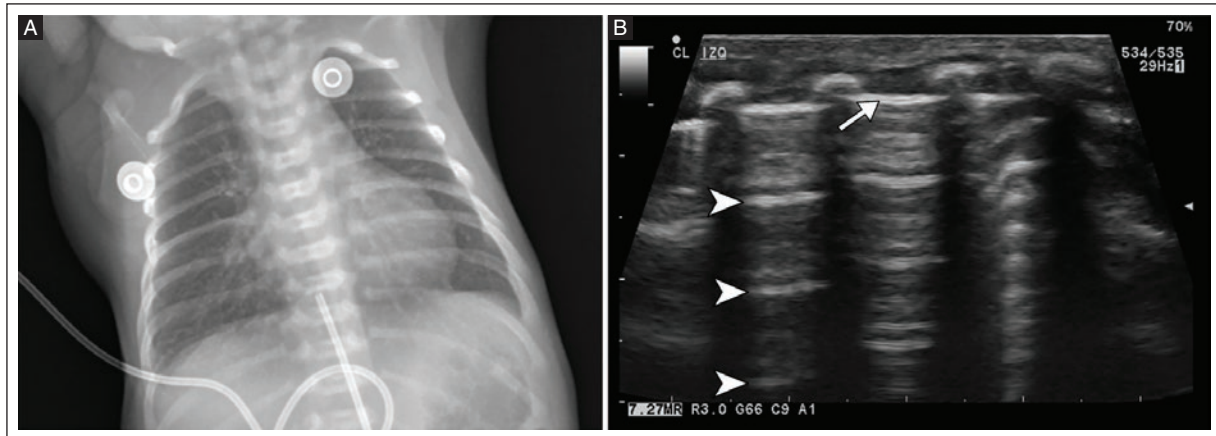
A healthy full-term neonate born by cesarean section at 39.5 weeks gestation with 24 hours of extrauterine life. A: a normal AP chest X-ray shows adequately expanded lungs with no abnormal findings. Umbilical catheter and electrodes are also visible. B: a normal lung POCUS shows a pleural line of normal thickness (white arrow) along with multiple A-lines (white arrowheads), which are typical findings in a normal lung. AP: anteroposterior; POCUS: point-of-care ultrasound; X-ray: radiography.
